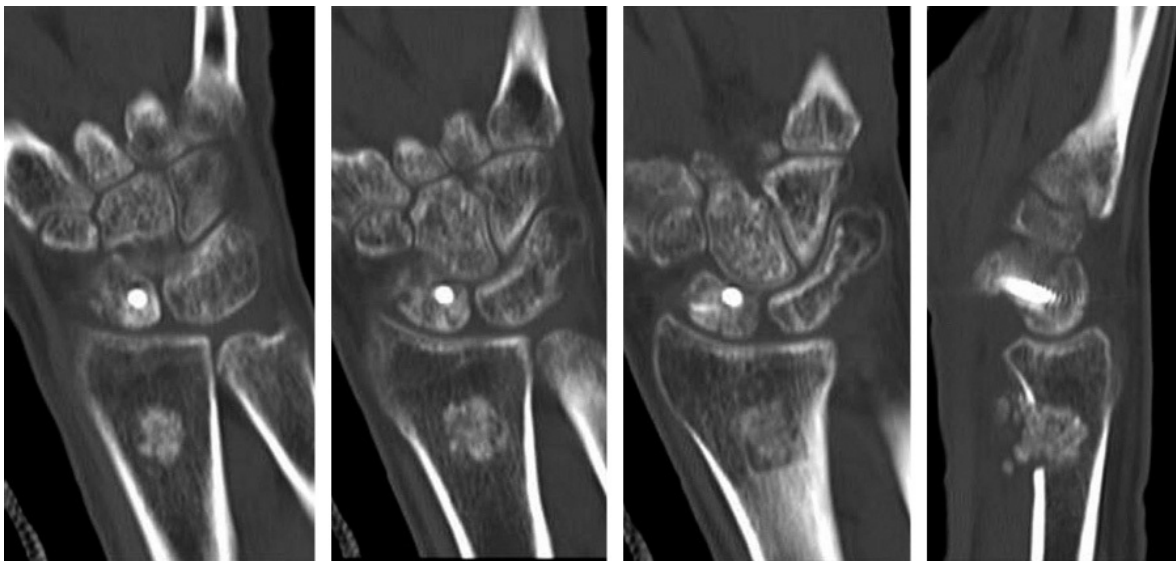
• CT scans obtained 6 weeks postoperatively after volar distal radius corticocancellous reconstruction of a scaphoid waist nonunion demonstrate healing across the proximal and distal autograft sites.
